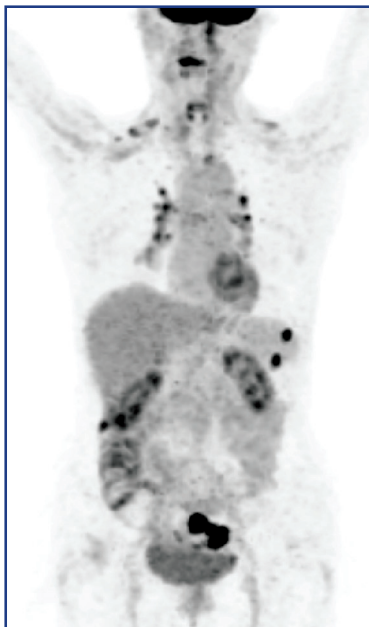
PET/CT image: New metabolically active lesions in the lymph nodes, the skin of the neck, and the abdominal wall
